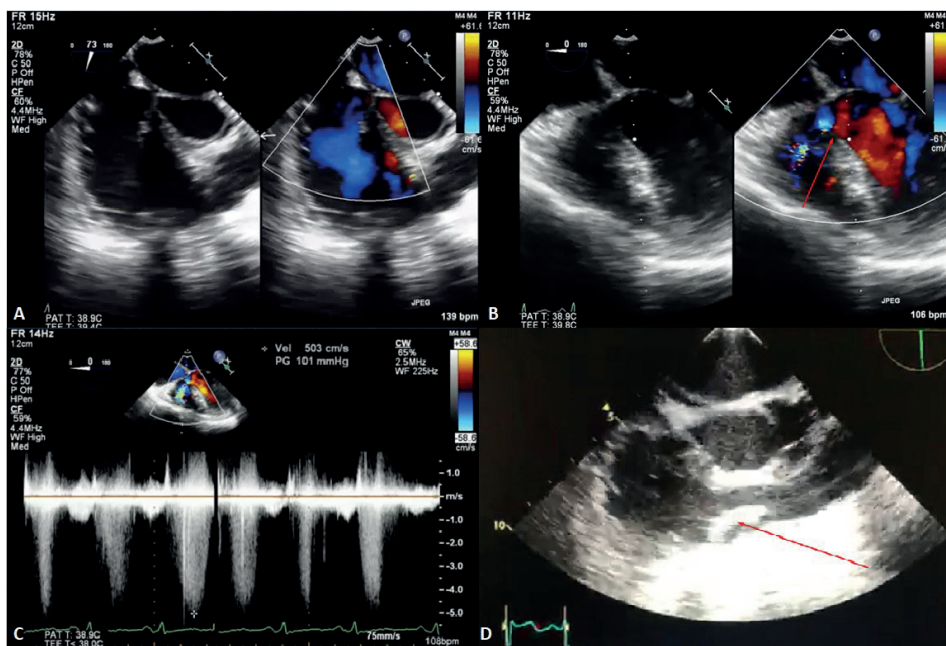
(2A, 2B, 2C, 2D) Transesophageal echocardiogram (TOE)
